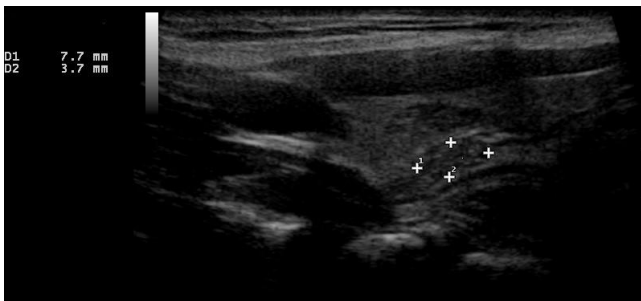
Left longitudinal B-mode ultrasound image of the neck. A hypoechoic heterogeneous lesion with punctate echogenic foci and hyperechoic linear striation is seen within the mid-pole of the left thyroid lobe measuring 7.7x3.7mm.
